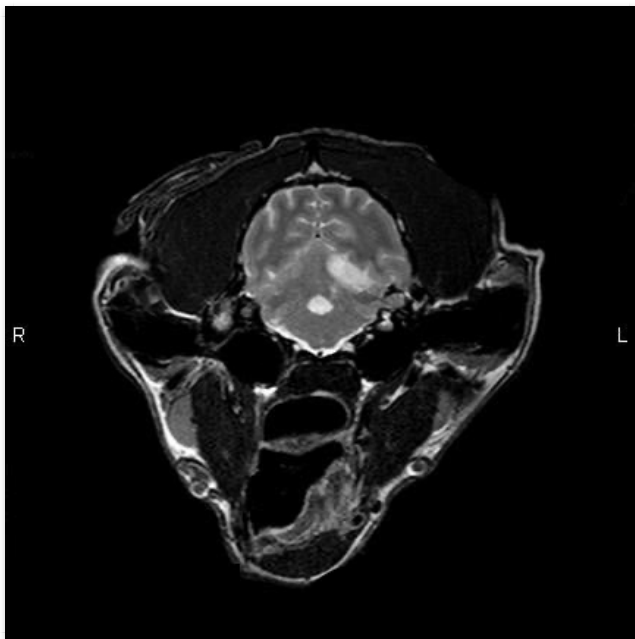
MRI T2W image of a brain infarct in a nine-year-old female, spayed greyhound showing a hyperintense lesion.
